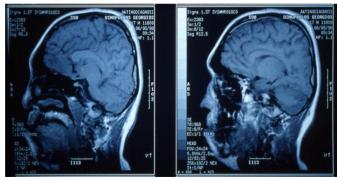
Lateral MRI tomography showing posterior displacement of maxillary sinuses.
